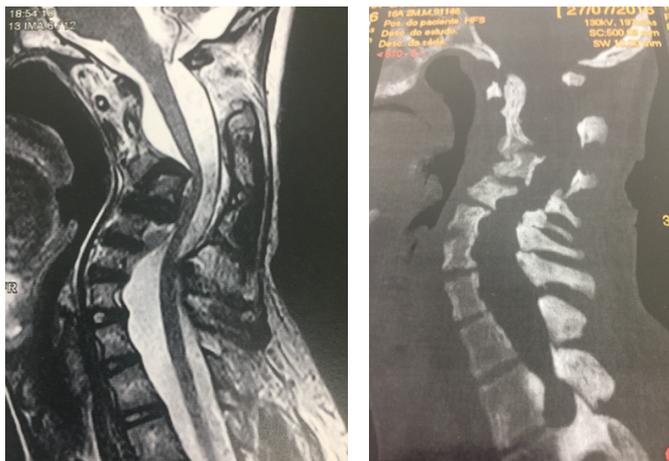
T2 Sagittal weighted MRI imaging showing spinal cord compression at C3-4 (a) and CT demonstrating dystrophic kyphosis (b)
